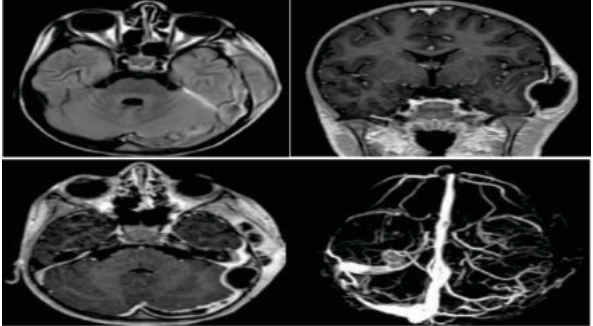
a) Axial FLAIR image showing extra axial intra and extra
